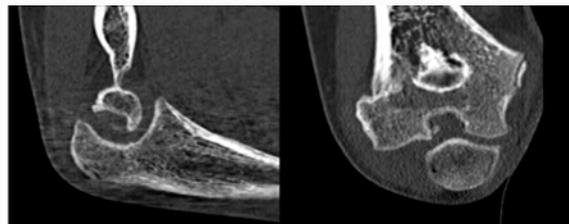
CT of the left elbow at 1 month after the diagnosis.
